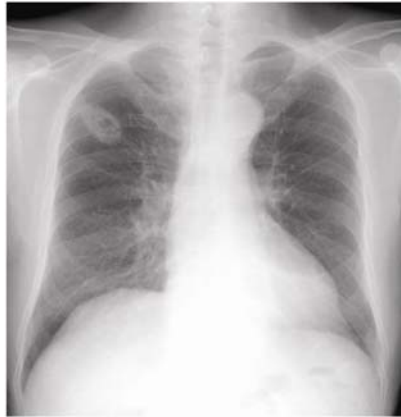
Chest radiograph taken on admission. Consolidation and a cavity are evident in the right upper area.
